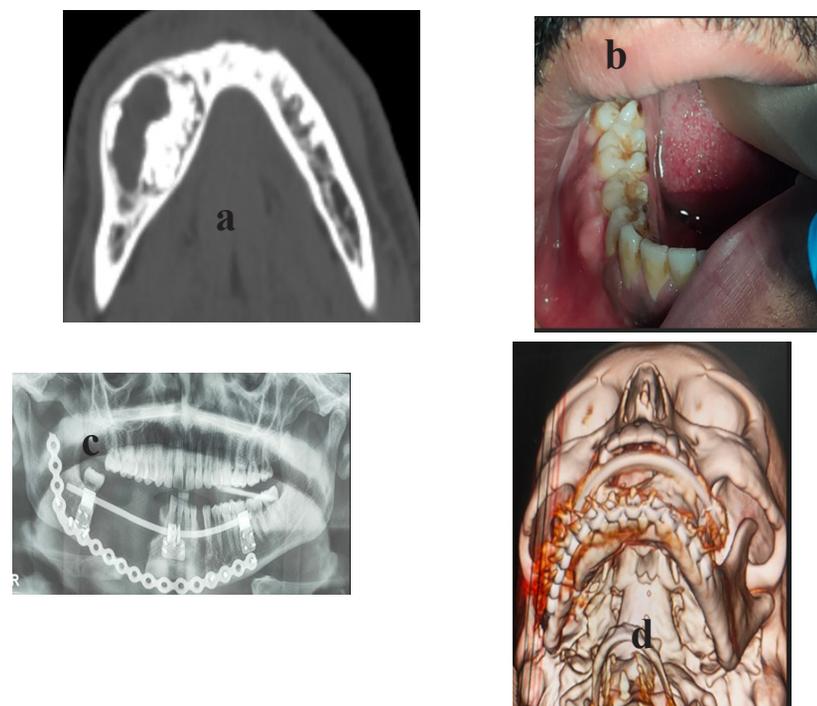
showing a axial section of ameloplastic fibroodontome, b photo swelling of the lower left site of mandible, c- defect before distraction, d- 3D CT showing reconstruction of the defect
